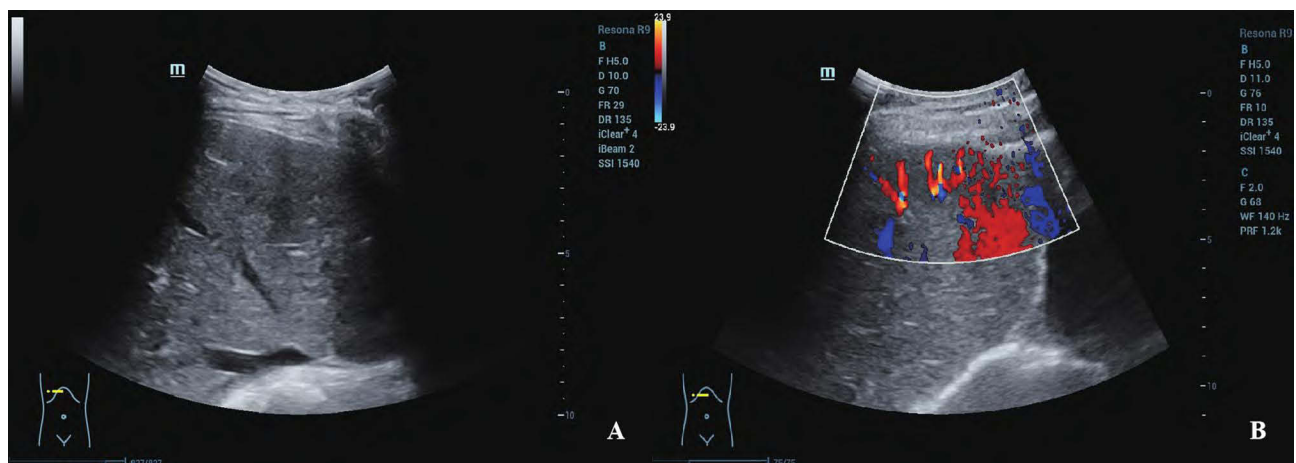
Abdominal Ultrasound of Liver Metastasis. (A) A 2D ultrasound image showing a hypoechoic liver lesion approximately 77 mm × 25 mm under the hepatic capsule in segment S4. (B) Color Doppler Flow Imaging (CDFI) highlighting blood flow around the lesion. This figure demonstrates the metastatic progression of the cancer, which was crucial in determining the need for Trastuzumab Deruxtecan (DS8201) treatment and symptom-focused nursing care.
